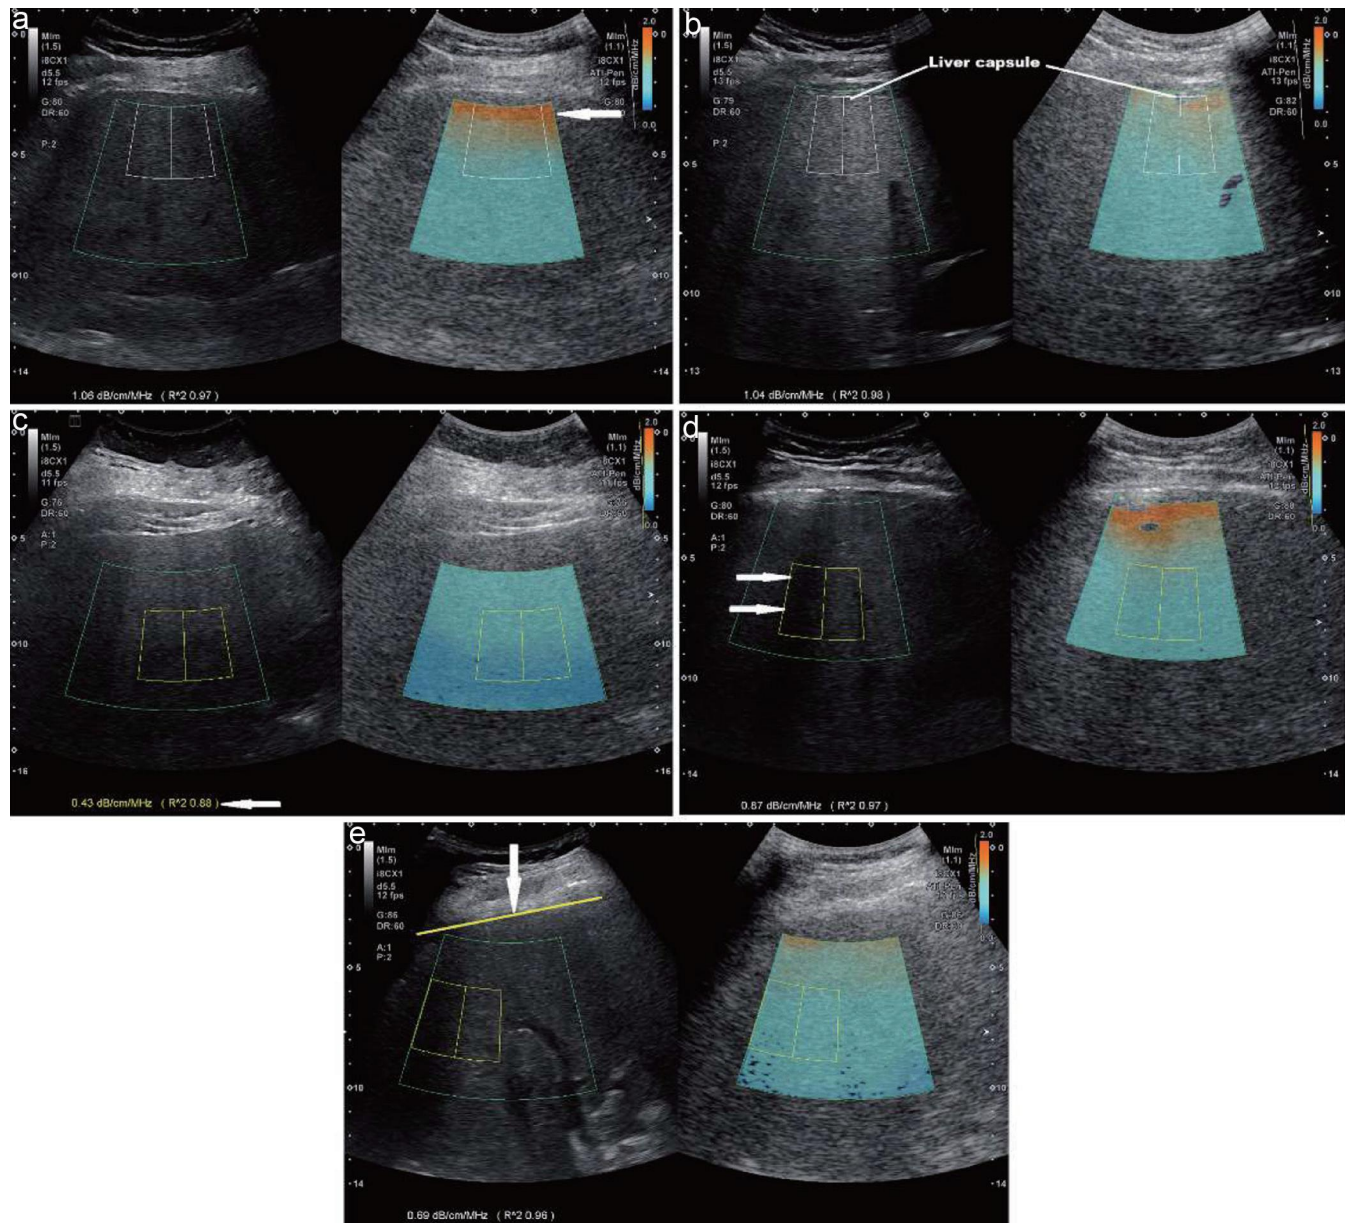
Technical errors in measuring liver attenuation coefficient (AC). Common technical errors in performing liver ultrasound attenuation imaging (ATI) are dark orange area (white arrow, a), the liver capsule (b), the region with blank color at the depth of >10 cm (c, the white arrow points $R^2 < 0.90$), and acoustic shadowing (white arrows, d) included in the measurement ROI. In addition, placing measurement ROI out of the center of the ultrasound attenuation imaging (ATI) image and/or sound beam (white arrow) to liver capsule (yellow solid line) off 90 degrees (e) may also maximize scattering sound energy to various directions resulting in measurement errors.
